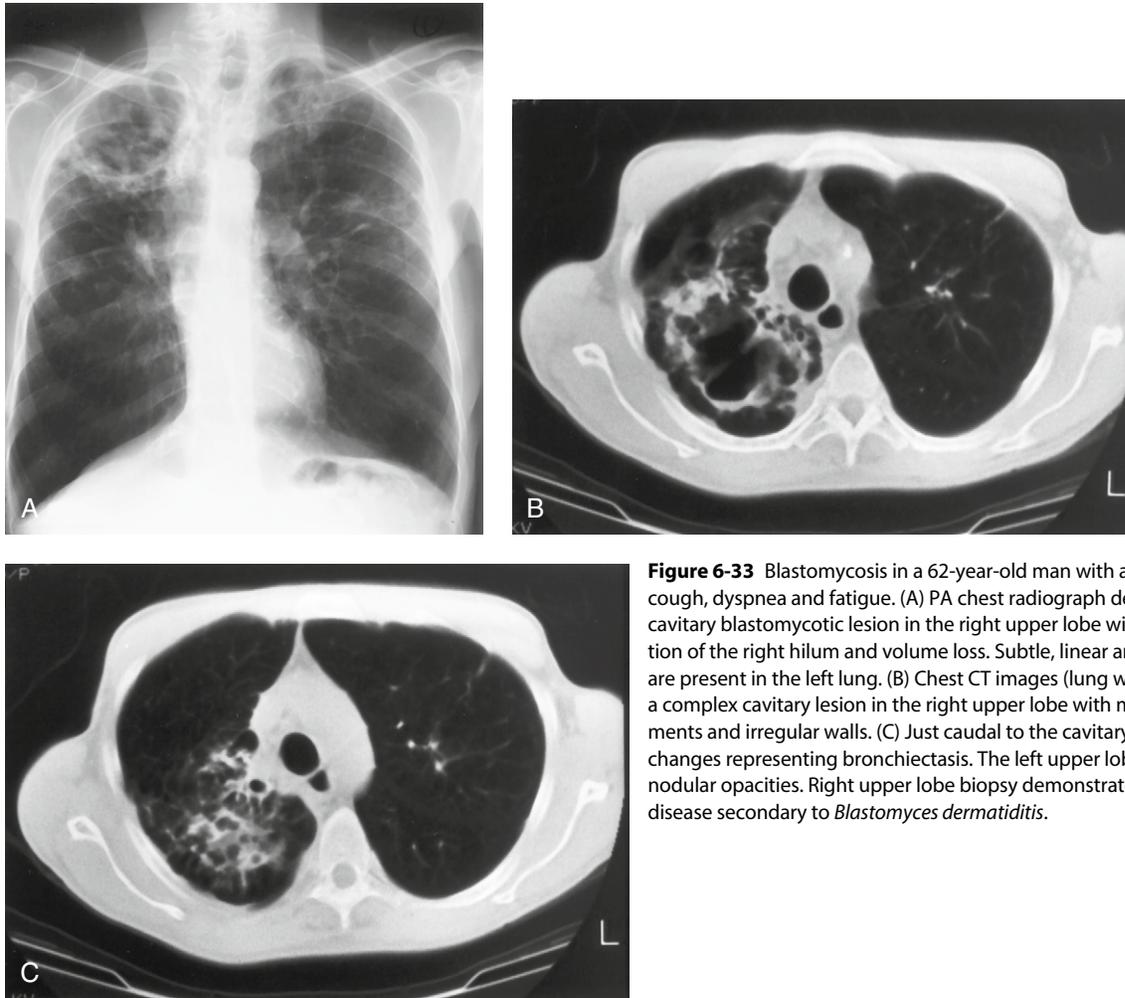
Blastomycosis in a 62-year-old man with a 6-month history of cough, dyspnea and fatigue. (A) PA chest radiograph demonstrates a large cavitary blastomycotic lesion in the right upper lobe with cephalad retraction of the right hilum and volume loss. Subtle, linear and nodular opacities are present in the left lung. (B) Chest CT images (lung window) demonstrate a complex cavitary lesion in the right upper lobe with multiple compartments and irregular walls. (C) Just caudal to the cavitary lesion are “cystic” changes representing bronchiectasis. The left upper lobe contains linear and nodular opacities. Right upper lobe biopsy demonstrated granulomatous disease secondary to *Blastomyces dermatitidis*.
